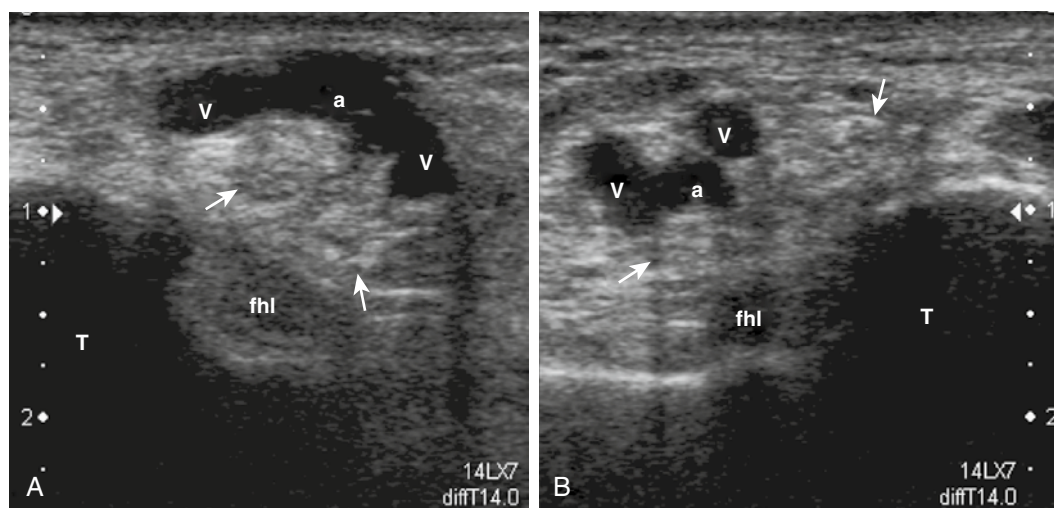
TARSAL TUNNEL SYNDROME. A, Short-axis, 5- to 14-MHz ultrasound image over the tarsal tunnel shows normal medial and lateral plantar nerves (arrows) trapped below a vascular arch made by a pseudo-aneurysm of the posterior tibial artery (a) and tibial veins (v); this compresses the tibial nerve and causes symptoms of tarsal tunnel syndrome without ultrasound nerve abnormalities. B, The corresponding short-axis ultrasound image shows the contralateral, asymptomatic tarsal tunnel with normal vessels. fhl, flexor pollicis longus tendon; T, talus bone.
